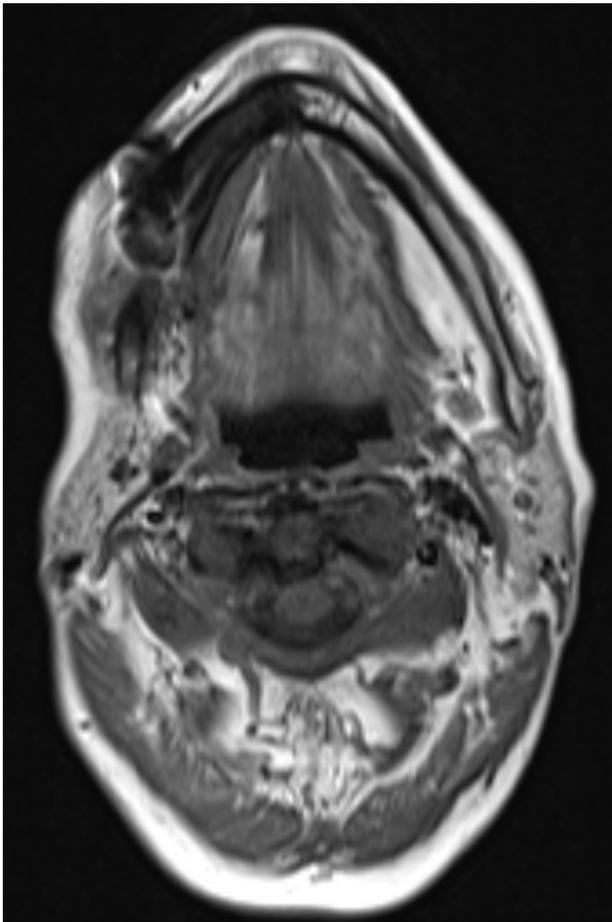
Magnetic resonance imaging can effectively differentiate osteomyelitis and bone metastasis in this patient. A linear contrast uptake in the periphery of the lesion with necrotic core suggested osteonecrosis accompanied with osteomyelitis. The lesion showed lower intensity in diffusion images unlike multiple metastatic lesions in the skull base and cervical vertebrae
